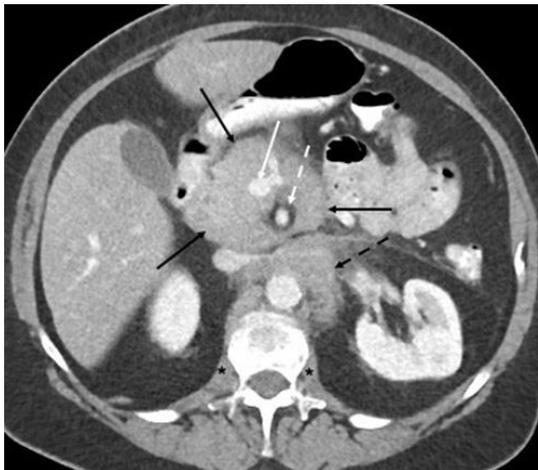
A contrast-enhanced CT abdomen of a 60-year-old female with lymphoma shows a confluent soft tissue density mass suggesting lymphadenopathy (solid and dashed black arrows) surrounding the SMA, SMV and abdominal aorta. Solid and dashed white arrows point to the SMV and SMA, respectively. The psoas major muscles lie adjacent to the vertebral body (asterisks)
